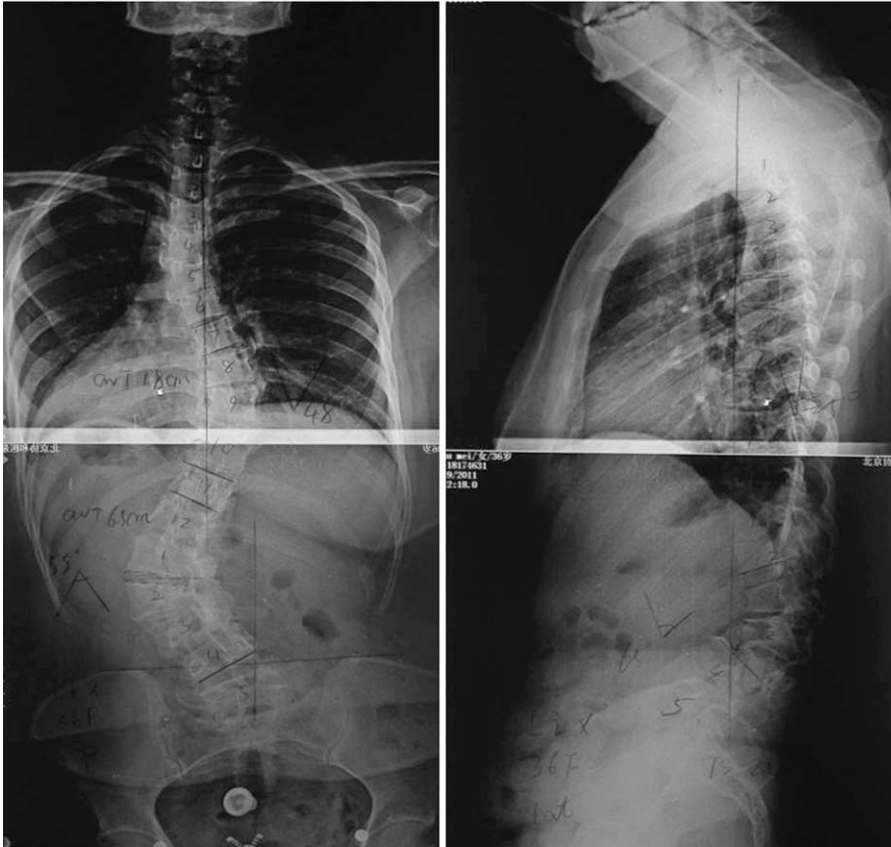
Preoperative standing anteroposterior and lateral radiographs.
